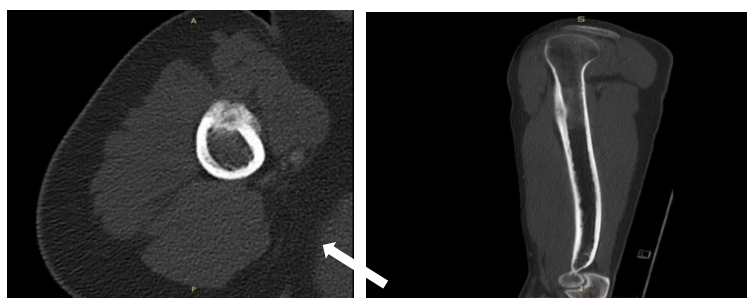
CT scan of the right upper limb with contrast – proximal third of the humeral diaphysis presents thickening of the anterior cortex; presence of a central bone nidus of 5.5 mm without obvious sclerotic reaction around the nest
